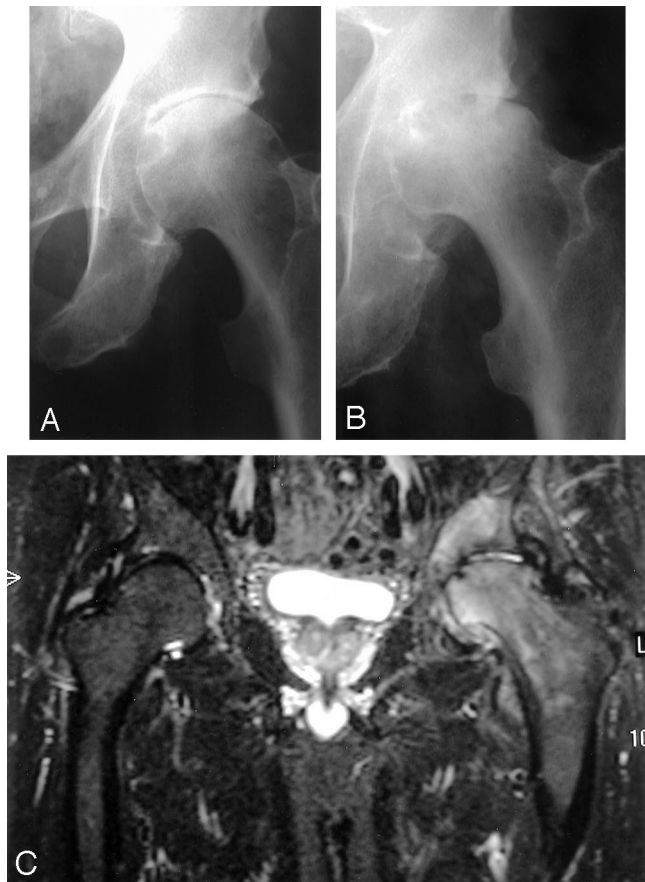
A, The osteoarthritis of the left hip was mild in the preoperative review of hips and spine. B, Radiograph showed collapse of the left femoral head, suggesting avascular necrosis. C, T2 STIR-weighted MRI scan of the hips shows evidence of collapse of almost the entire cortical surface of the left femoral head with edema on both sides of the joint and a small effusion. The appearances are entirely consistent with end-stage avascular necrosis. The right hip appears normal.
